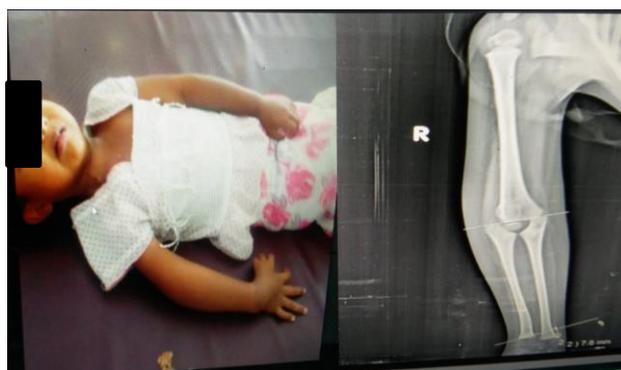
(A) Shown right upper limb with seven fingers; (B) X-ray right upper limb show two ulnar facing each other and the medial ulnar in longer.
